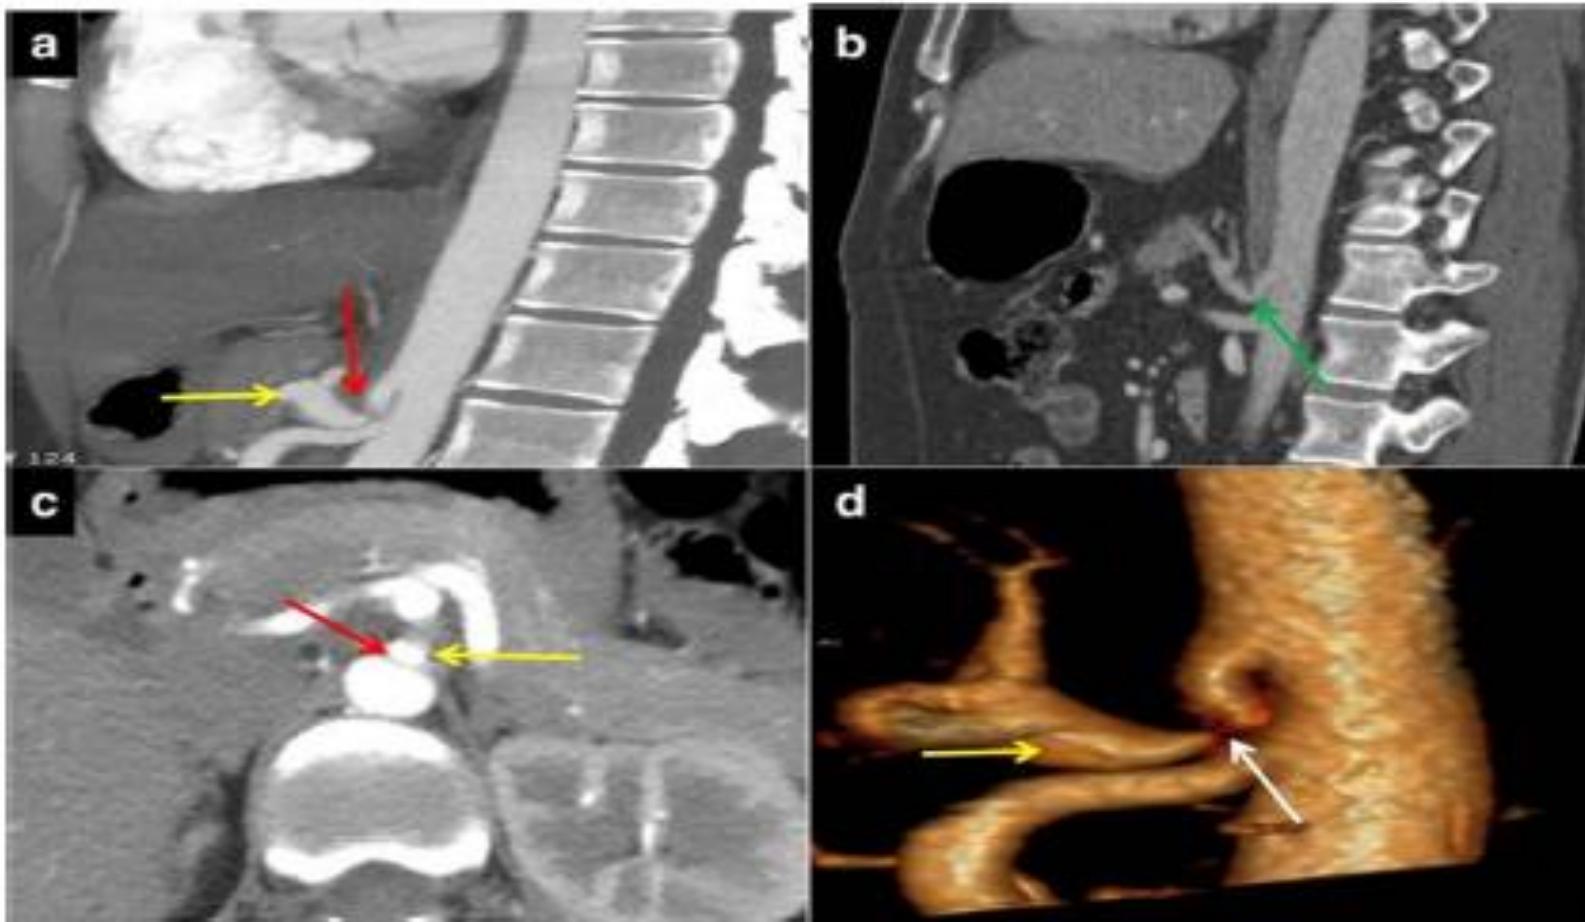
Median arcuate ligament syndrome in a 47-year-old female with chronic post-prandial upper abdominal pain. CT angiography images of the same patient in a sagittal reformatted MIP image of arterial angiogram, b sagittal reformatted MPR image of end-inspiratory phase, c axial reformatted MIP image of arterial angiogram, and d volume rendered 3D reconstructed image. “Hooked” appearance of the proximal celiac artery
